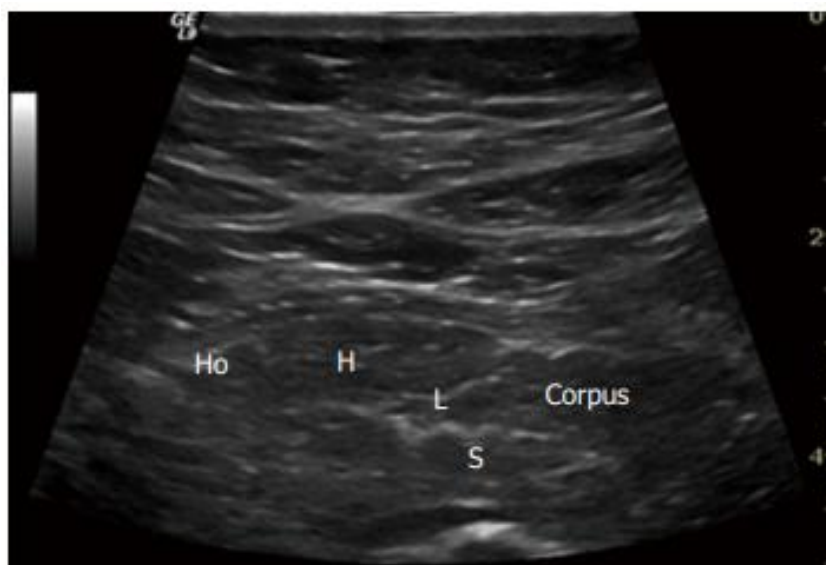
Left US image, right CT scan* <sup>29</sup>
